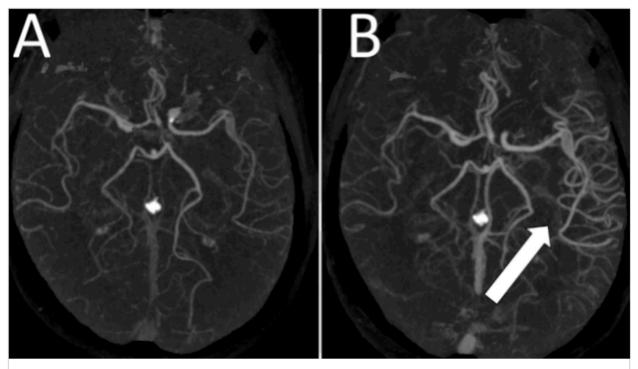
Contrast-enhanced CT-angiography of the head showing imagery acquired before the patient underwent a carotid endarterectomy (part A) and during the patient's admission to the emergency department (part B), where there is increased vascularisation on the left side hemisphere (arrow).
